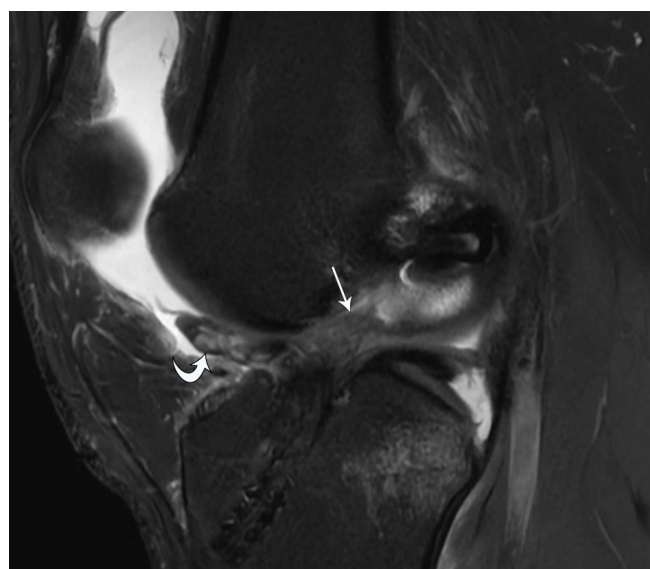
20-year-old male with complete ACL graft rupture. Sagittal proton-density-weighted fat-suppressed MR image shows complete disruption of the ACL graft (arrow) with anteriorly displaced torn graft fibers (curved arrow)
